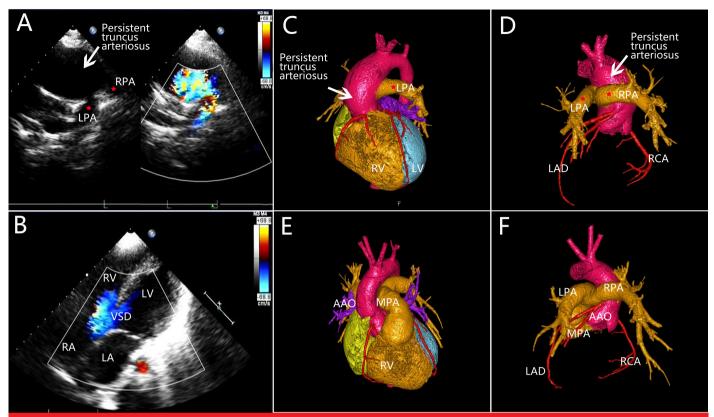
Multimodal images of a 15-year-old girl diagnosed with type I persistent truncus arteriosus with ventricular septal defect who underwent surgical correction. (A-B) Transthoracic echocardiography shows a single widened arterial trunk with 2 separate pulmonary artery branches originating from the posterolateral wall of the arterial trunk and a large ventricular septal defect beneath the common arterial valve. (C-D) Preoperative computed tomography angiography volume rendering shows the left and right pulmonary arteries directly arising from the dilated posterolateral wall of the arterial trunk. (E-F) Postoperative computed tomography angiography volume rendering shows patency of the right ventricular outflow tract and artificial graft, with marked reduction in right ventricular size and significant improvement in ascending aorta dilation compared to preoperative images. AAO, aorta; LAD, left anterior descending coronary artery; LPA, left pulmonary artery; LV, left ventricle; MPA, main pulmonary artery; RCA, right coronary artery; RPA, right pulmonary artery; RV, right ventricle.
